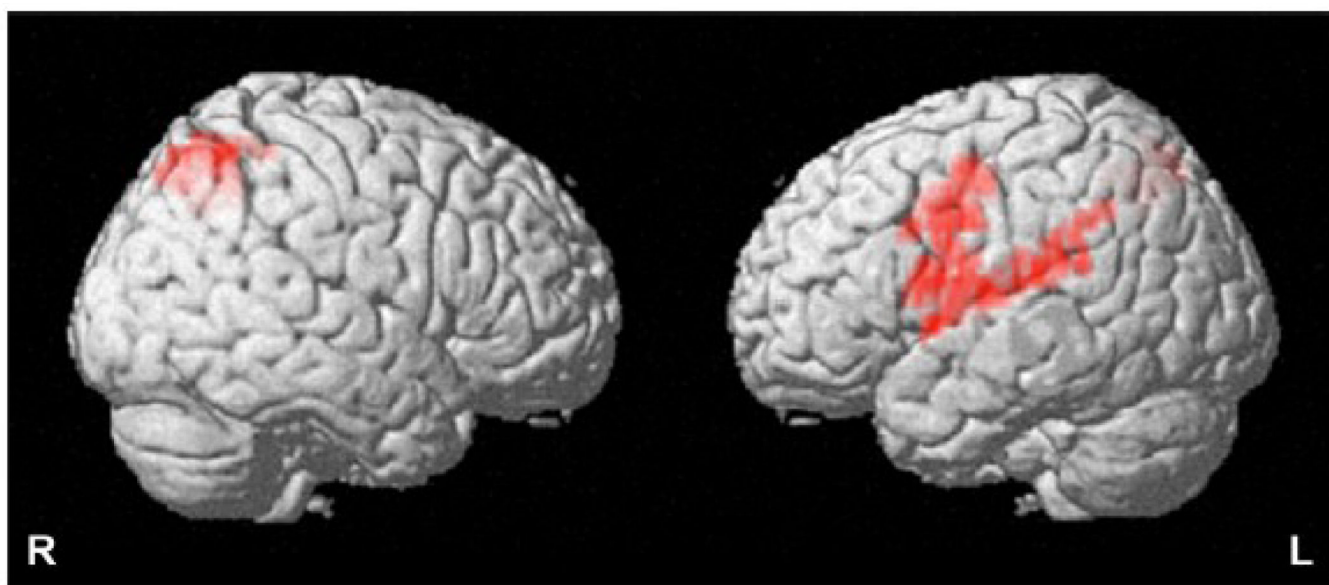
Spatial distribution of brain functional MRI activation that were positively correlated with accuracy during sDSST task performance
